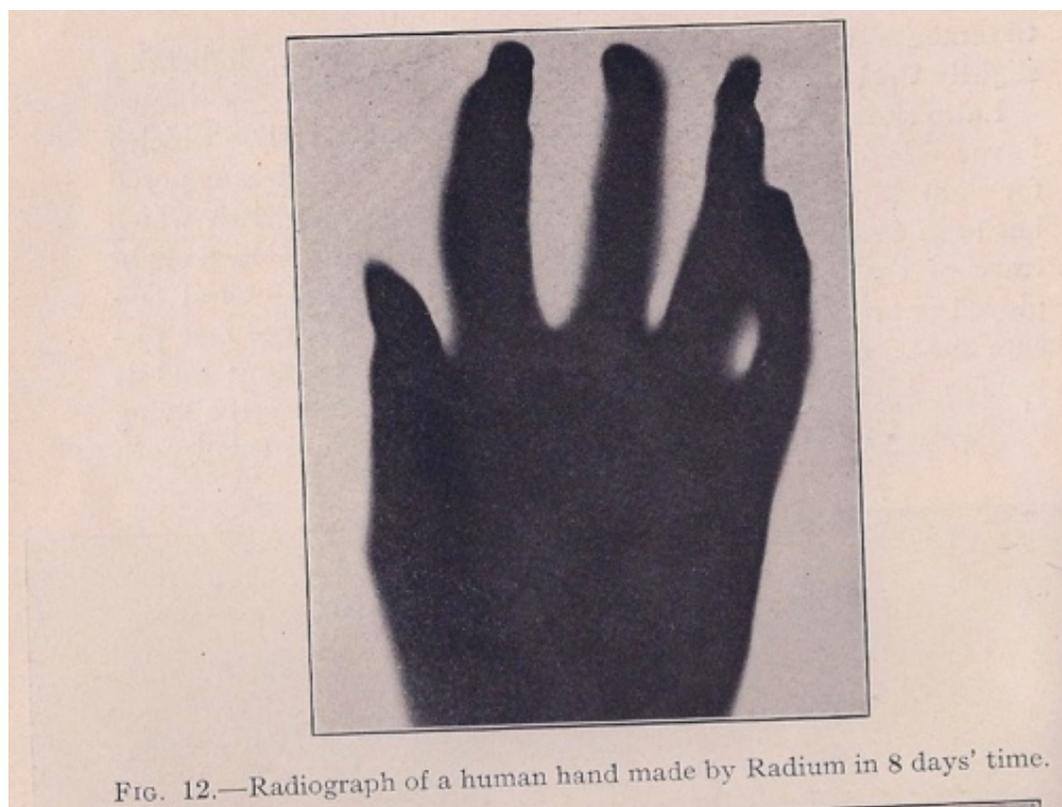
Radiograph (photographic exposure with radium) of a human hand, created by Hammer and shown during his lectures. This would have immediately reminded his audience of the famous X-ray photograph of the hand of Röntgen's wife, that clearly showed her bones and wedding band. Hammer, Radium, and Other Radio-Active Substances: 38.
